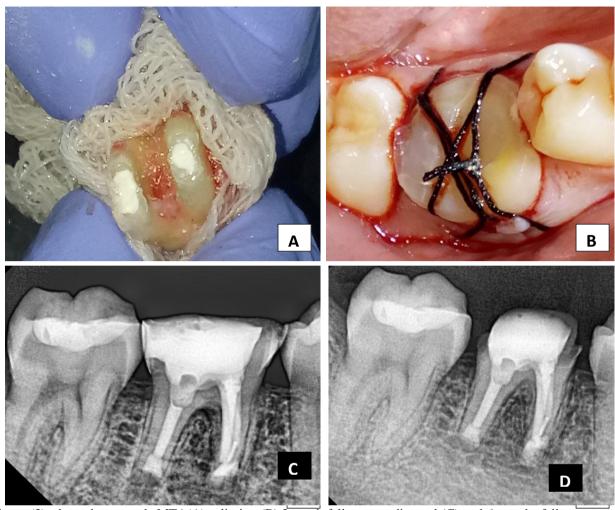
showed retrograde MTA(A), splinting (B), 3month follow up radiograph(C) and 6 months follow up radiograph(D).
